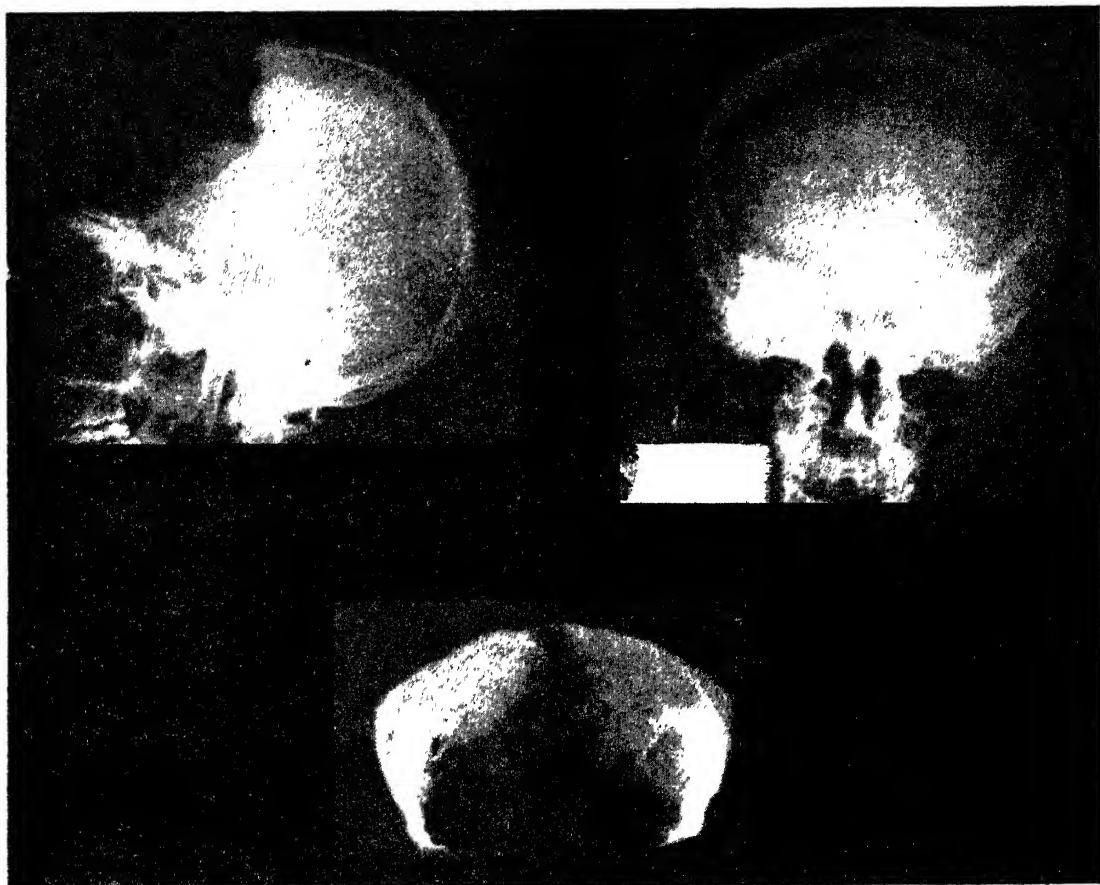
Postoperative x-ray pictures of the anteroposterior and lateral views, showing the frontal skull defect and the excised bone fragments (November 18, 1943). (Schnitker, M. D. and McCarthy, M. D.: Surgery 18: 94 (July) 1945.)
